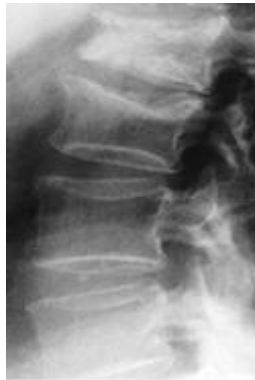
X-ray image of compression fracture at two levels
